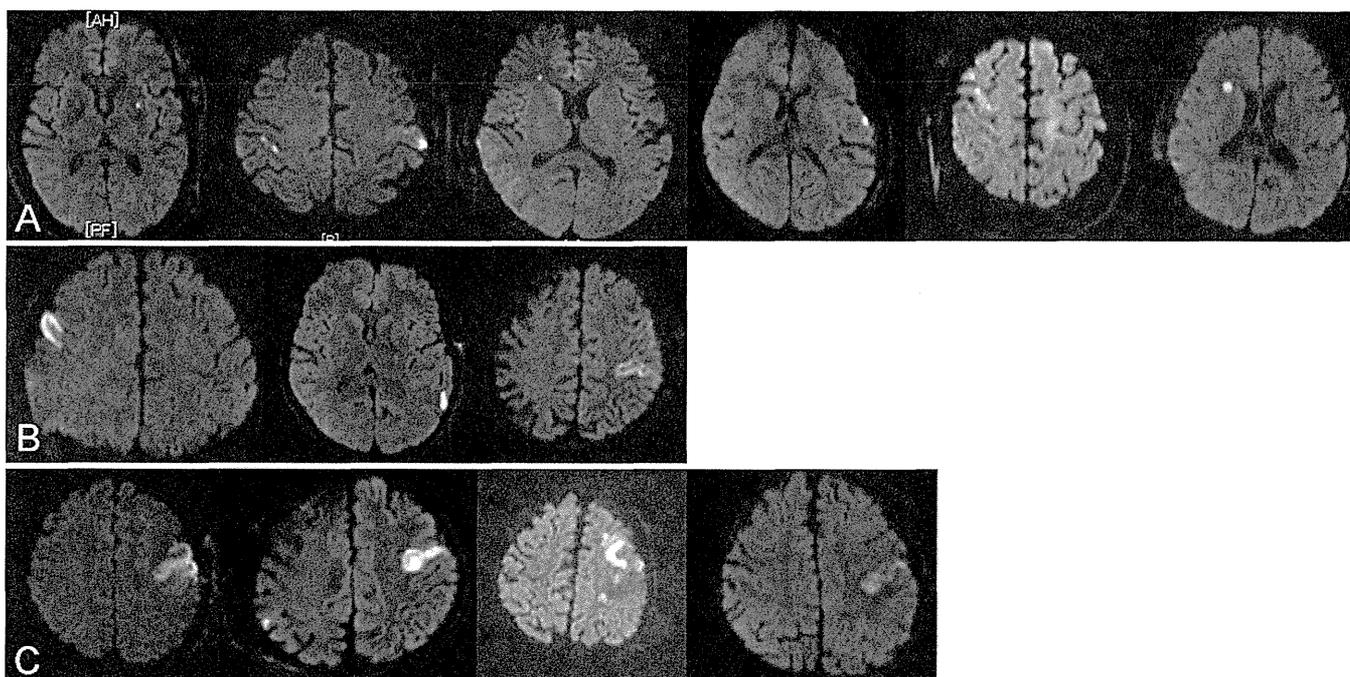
Lesions detected on postoperative DWI. A: Silent lesions. B: Lesions causing transient symptoms. C: Lesions causing permanent symptoms.
